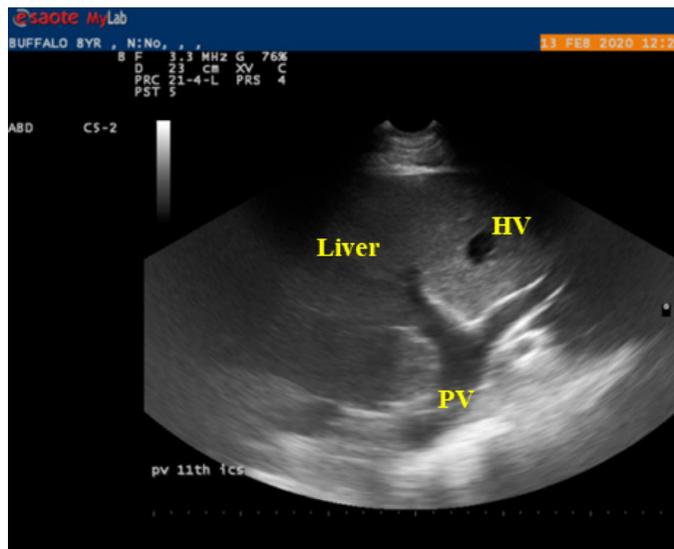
Doppler sonogram of liver at 11th ICS showing portal vein (PV) ventrolateral to the caudal vena cava (CVC) and hepatic vein (HV) in the 12th ICS.
